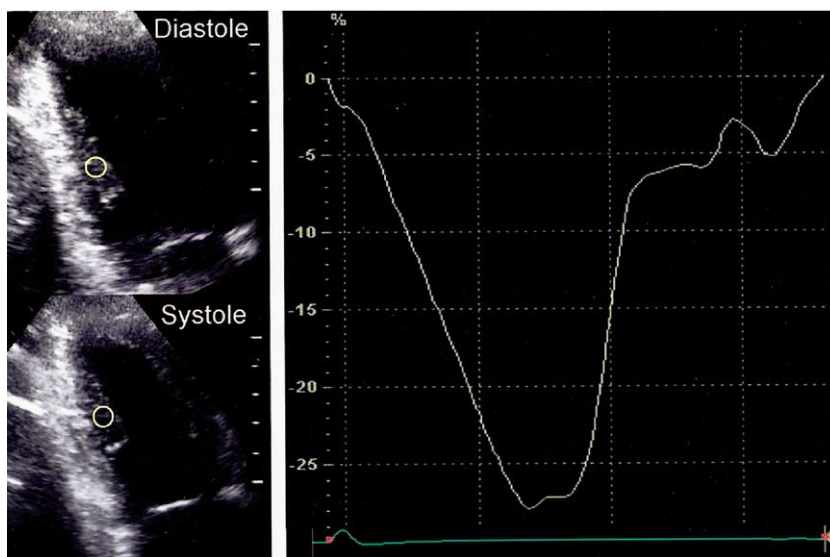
Methods used to evaluate papillary muscle (PM) function. Normal systolic PM thickening seen by two-dimensional echocardiography is shown in the left upper and lower panels and the right panel shows normal systolic PM longitudinal shortening as assessed by tissue strain imaging.
